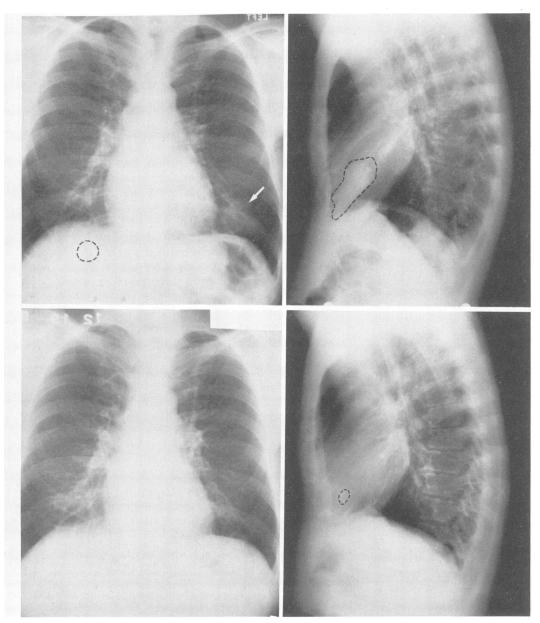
Top, Chest roentgenogram showing definite lingular infiltrate (arrow) and probable right lower lobe infiltrate (dotted circle). Bottom, Chest roentgenogram four months later showing resolution of right lower lobe infiltrate and nearly complete resolution of the lingular process (dotted circle).
